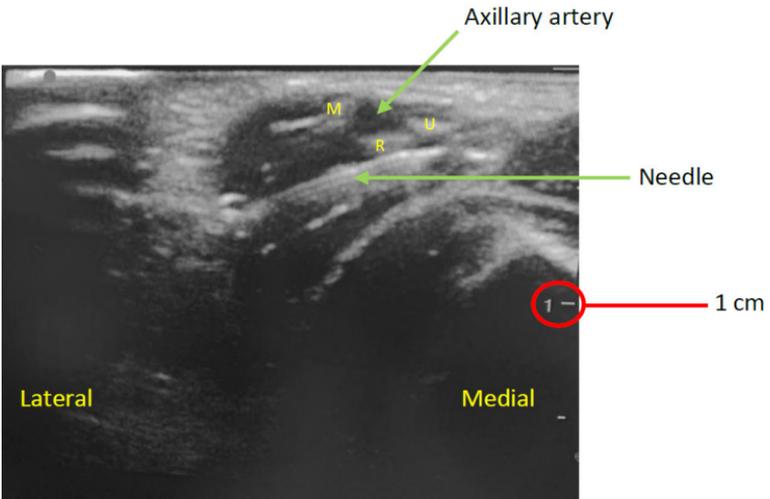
Ultrasound image after initiation of local anesthetic injection.
